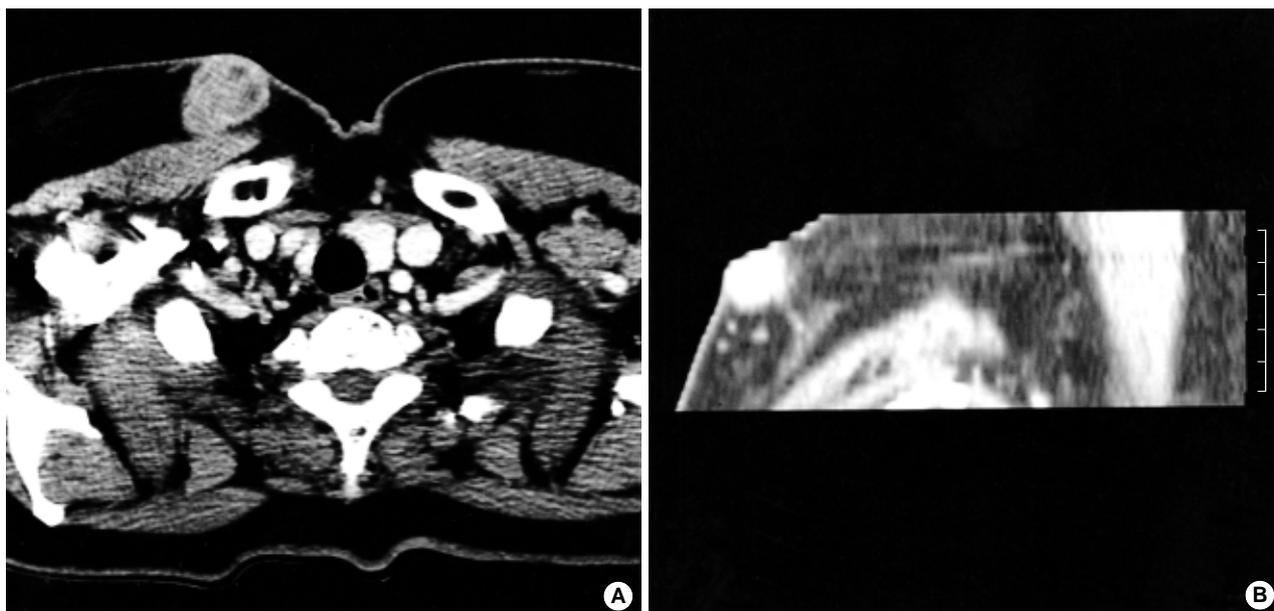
(A) Postcontrast CT demonstrates a round mass with inner low densities and focal peripheral rim enhancement, and overlying skin thickening in the right upper anterior chest wall. (B) Oblique sagittal reconstruction image of CT shows a separate subcutaneous mass from pectoral breast parenchyma.
